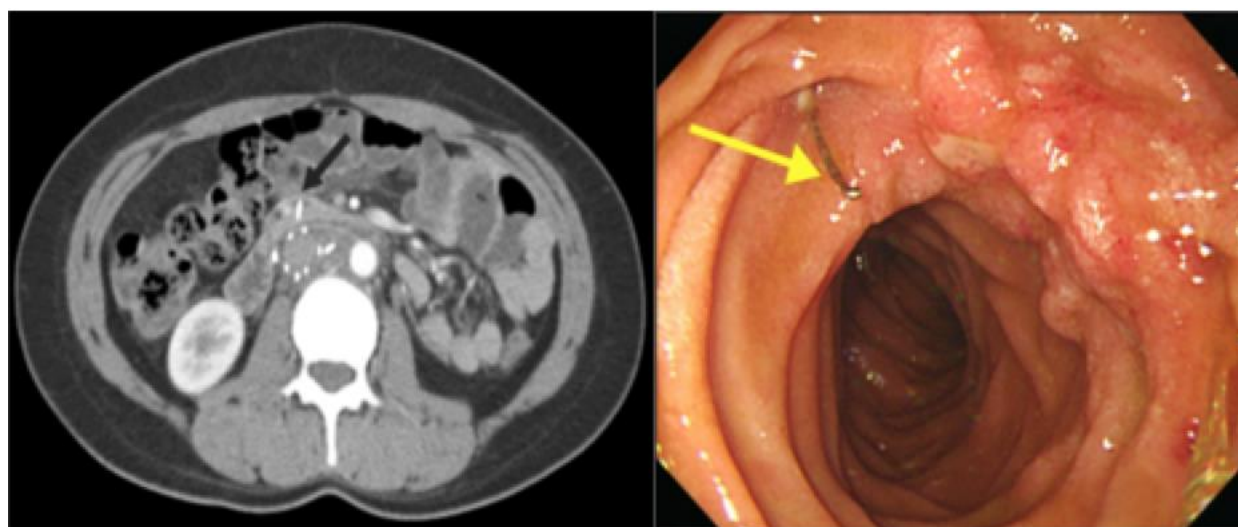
MRI visualization (left) of an implanted IVC filter leg (black arrow) protruding into the duodenum. Lumen endoscopy showed IVC leg (yellow arrow) protrusion and scarring on opposite side membrane (adapted from Bae *et al.*).¹⁴
